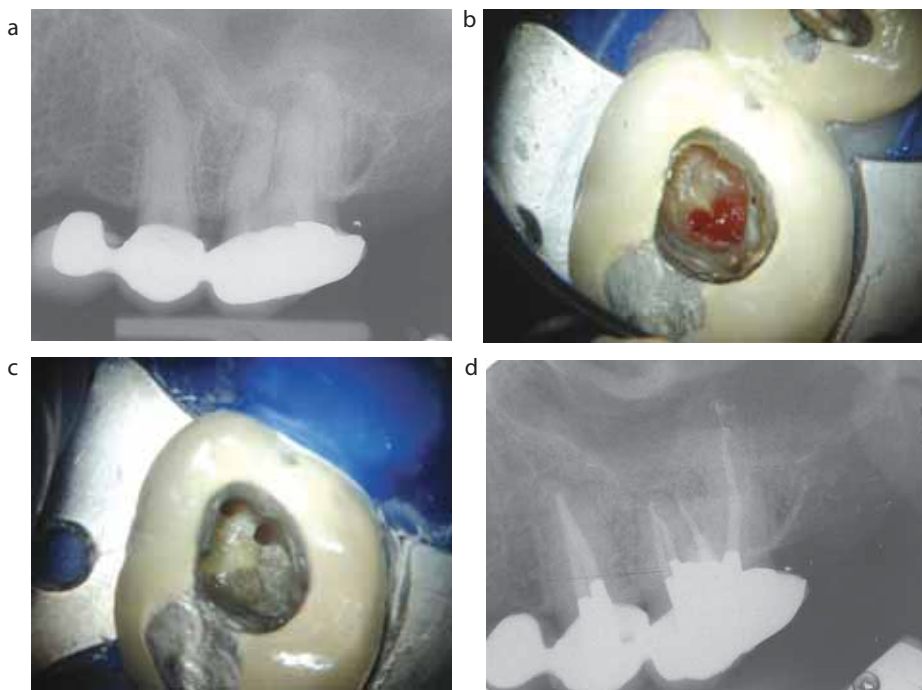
Case showing furcal repair using grey MTA: (a) pre-operative radiograph; (b) photograph of perforation site; (c) MTA repair; (d) postoperative radiograph. No barrier was used in this case and some furcal extrusion can be seen; this was uneventful.
